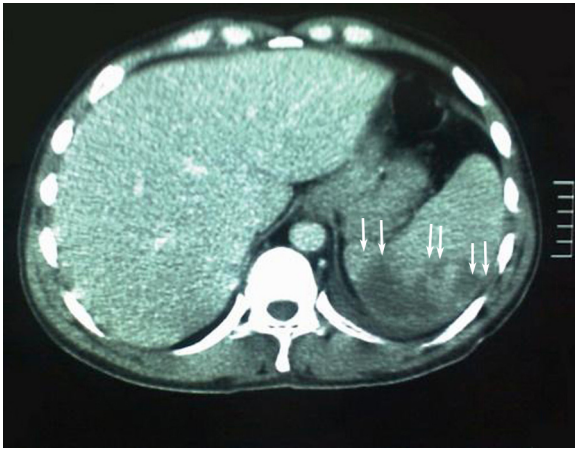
Computed tomography of the patient demonstrating splenic infarcts (white arrows), due to arterial emboli, which constituted a major complication of the infective endocarditis in this patient.
